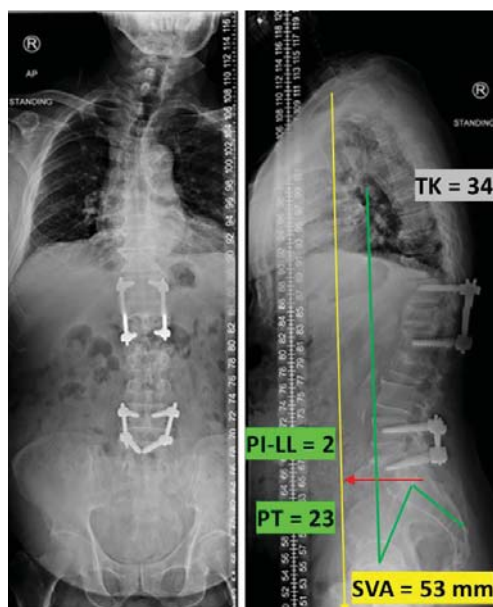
Standing spine radiographs at 1 year after surgery. Films show the bony fusion at the upper end plate of L5 vertebra and no loss of reduction. The patient was able to maintain corrected spinal alignment and had no hardware complications. Spinopelvic parameters were SVA 53 mm; PT 23°; PI-LL 2°; and TK 34°.
